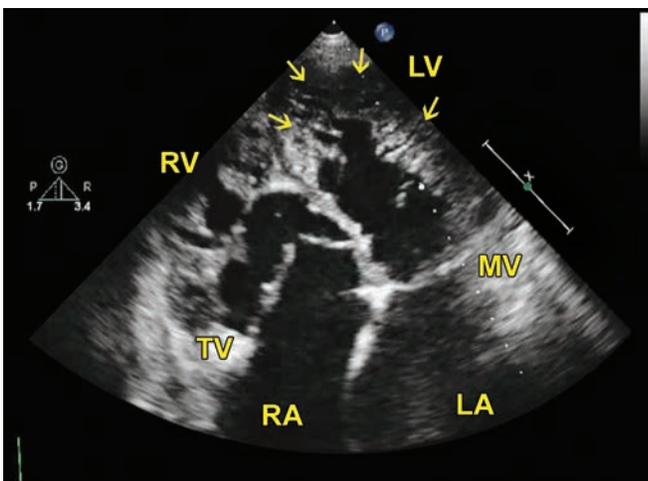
Apical 4-chamber view shows significant apparent displacement of the attachment of the septal tricuspid valve leaflet as compared to the anterior mitral leaflet. Arrows point to multiple trabeculations in the left ventricle consistent with noncompaction.
